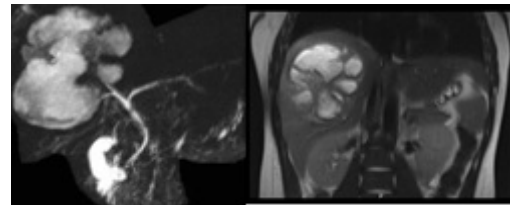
(Day 1) MRI with and without contrast on admission: multi-loculated complex fluid collection in the right hepatic lobe measuring approximately 13.6 cm x 8.2 cm x 10.1 cm.
